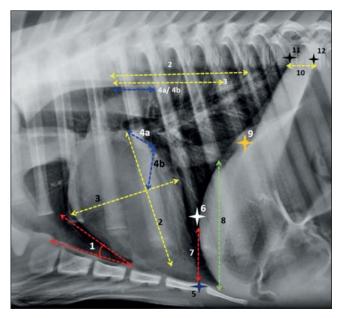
Radiograph showing cardiac and diaphragm parameters measurements; the cardiac inclination angle (1), the heart length in long axis (2), the heart width/short axis (3), the measurement for VLAS_a and VLAS_b (4a and b), the cupula at sternum (5), the rib at cupula (6), the height of cupula from sternum (7),), the height of CVC when it enters diaphragm from sternum (8), the rib where the CVC enters diaphragm (9), the distance between crura (10), the cranial crus at thoracic vertebra (11), the caudal crus and thoracic vertebra (12).
